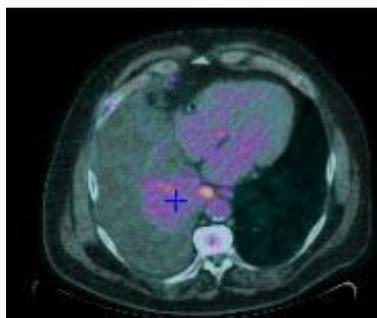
PET-CT (07/11/2018): Intensely hyper metabolic right posterior and paramedian thoracic lesion, infrahilar, accompanied by an intensely sub carinal hyper metabolic adenopathy. Large right pleural effusion, not hyper metabolic.
